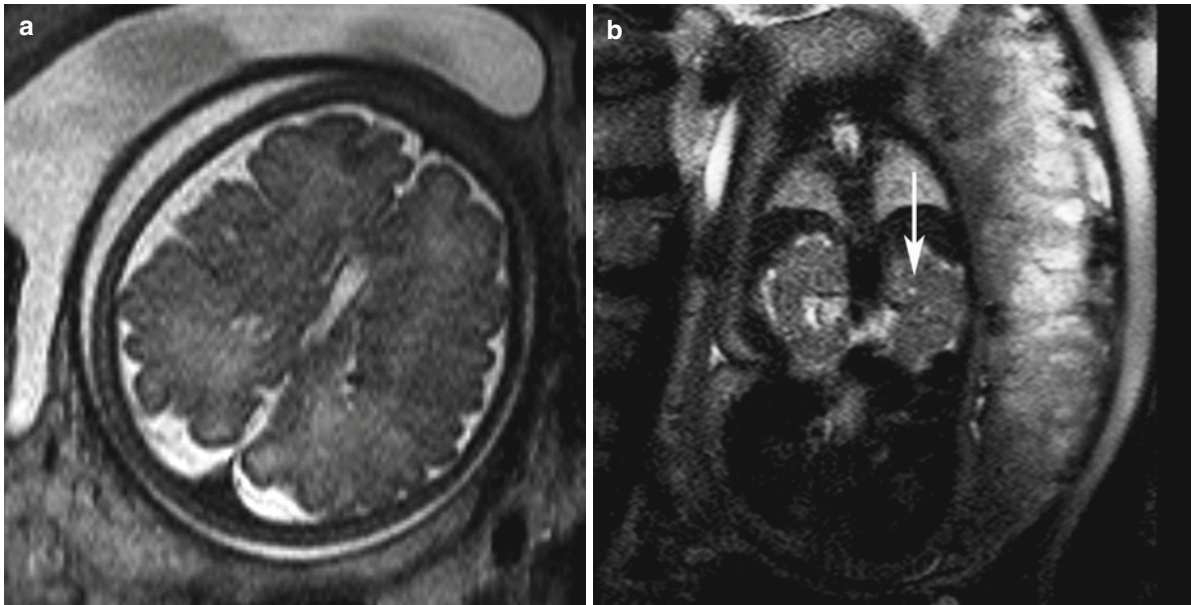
Bourneville Pringle syndrome at GW 33+1. (a) Subependymal nodules, right frontal focal cortical dysplasia (axial T2-weighted image); (b) the kidneys with small cysts (arrow, coronal T2-weighted image)
